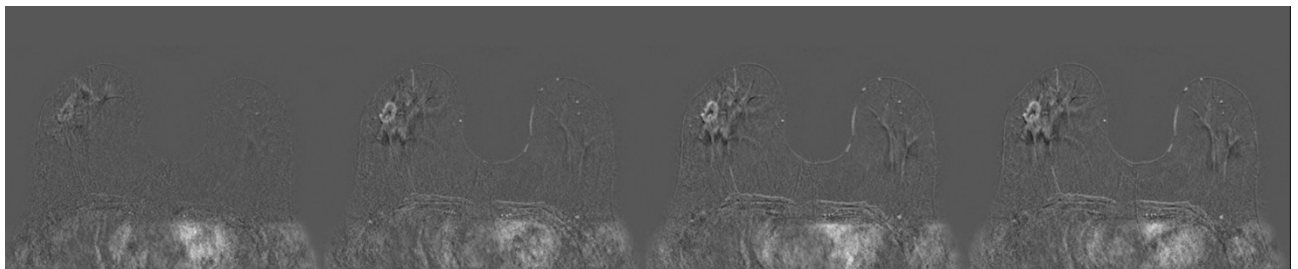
Breast MRI, axial subtracted image from the dynamic T1 weighted gradient-echo series, rim enhancement of mass lesion in the inferior inner quadrant
